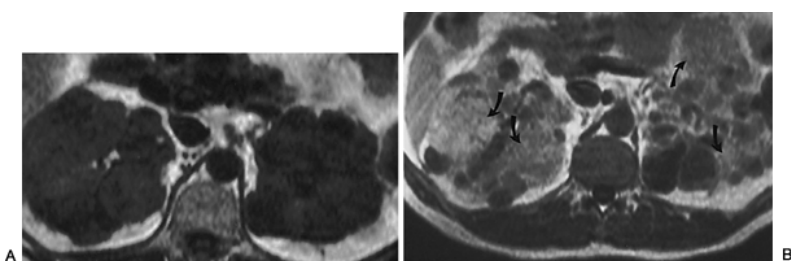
3. Use of gadolinium-enhanced magnetic resonance imaging (MRI) scan for detecting renal masses in renal failure. This 38-year-old patient was thought to have autosomal-dominant polycystic kidney disease. When a family member was discovered to have symptoms of von Hippel Lindau disease, he was reevaluated. Because of his renal failure, gadolinium-enhanced MRI was performed. A: Precontrast T₁-weighted image demonstrates enlarged kidneys with a typical appearance of autosomal dominant polycystic kidney disease. B: Contrast-enhanced MRI, however, demonstrates multiple areas of enhancement consistent with renal cell carcinomas (*arrows*). This was confirmed surgically by bilateral nephrectomy and subsequent transplant.
